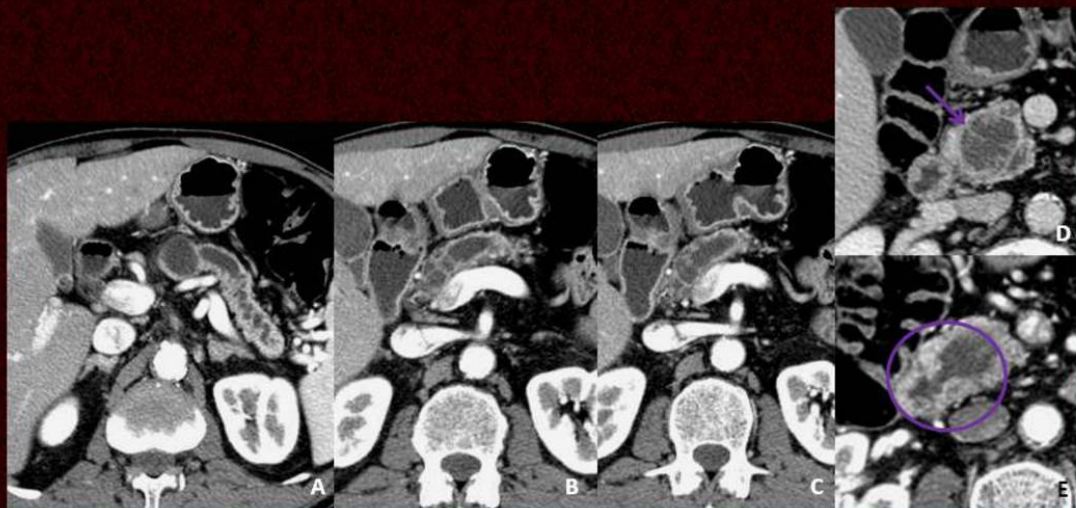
Main duct IPMT. CT scan performed in this 61-year-old asymptomatic male patient reveals a tortuous dilatation of the pancreatic duct which communicates with a complex cystic lesion in the pancreatic head. Note the presence of tiny enhancing solid elements in the lesion (arrow) and the bulging papilla projecting into the duodenal lumen (circle).
